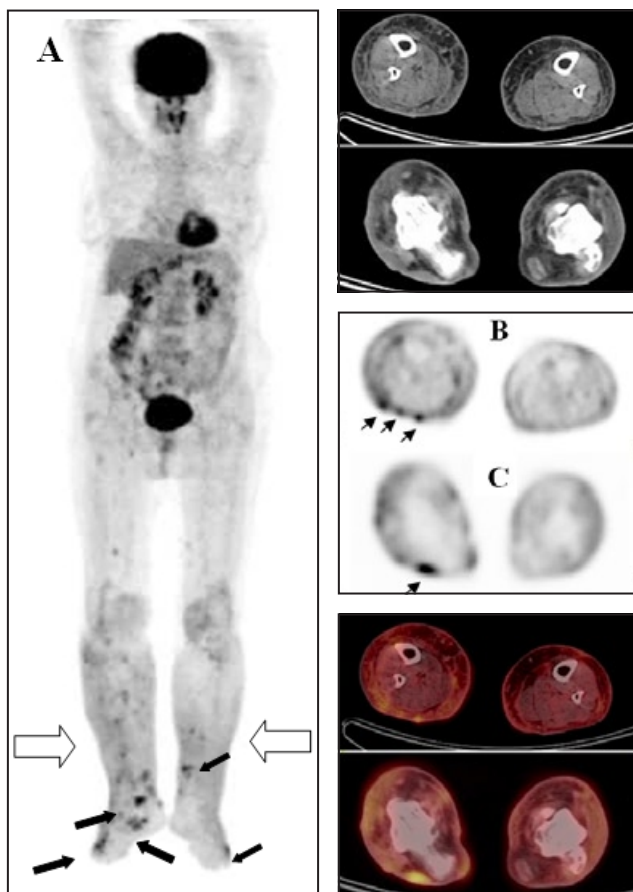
Second case, multifocal increased ^{18}F -FDG uptake in dermal and subdermal regions, representing ulcerated plaques disseminated on the distal portions of both legs are shown in anterior position of MIP image (black arrows, A), in axial section at the mid thigh (arrows, B) and at proximal heel level (arrow, C). Bilateral diffuse ^{18}F -FDG uptake seen in the distal portions of legs suggesting lymphedema and venous stasis was also notable (bold white arrows in A).
